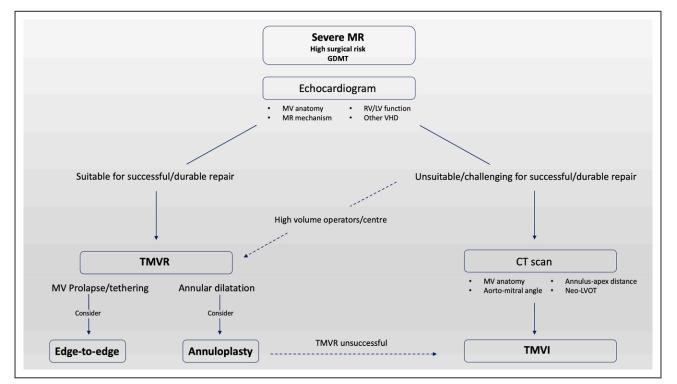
Proposed decisional algorithm for transcatheter therapies correcting mitral regurgitation (MR) in native mitral valve (MV). CT indicates computed tomography; GDMT, guideline-directed medical therapy; LV, left ventricle; LVOT, left ventricle outflow tract; RV, right ventricle; TMVI, transcatheter mitral valve implantation; TMVR, transcatheter mitral valve repair; and VHD, valvular heart disease.
